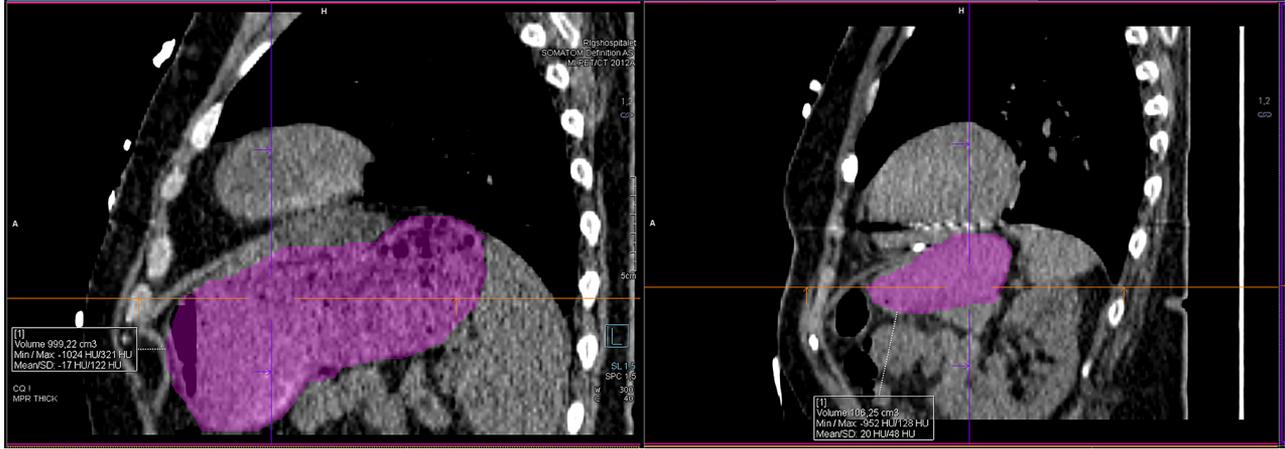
A comparison of a large and a small stomach shown in computed tomography (Left: 999 cm³; Right: 136 cm³).
